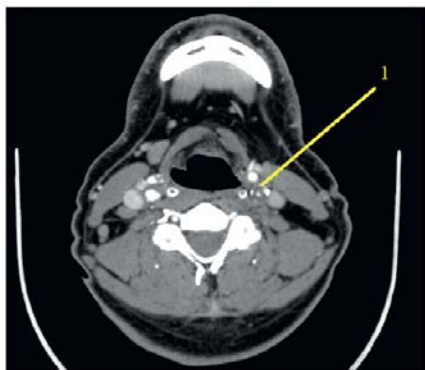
Multislice computed tomography — angiography of brachiocephalic artery: 1 — subocclusion of internal carotid artery on the left
